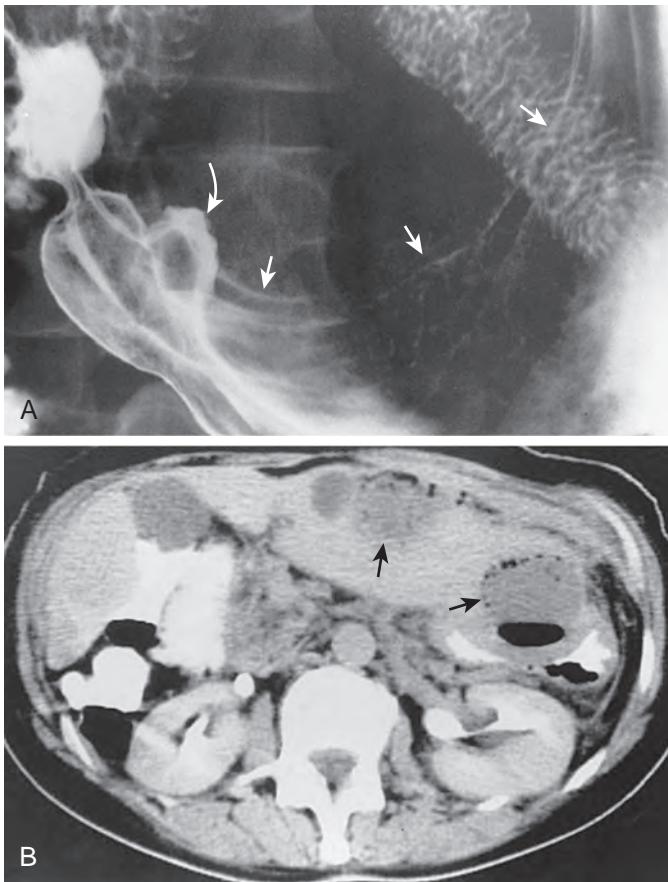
Penetrating lesser curvature ulcer with an associated hepatic abscess. A. Barium study shows a deep ulcer (curved arrow) on the lesser curvature of the distal antrum. Also note the large area of extrinsic mass effect (straight arrows) on the adjacent gastric wall. B. CT scan reveals several gas- and fluid-containing abscess cavities (arrows) in the left lobe of the liver. These abscesses were caused by penetration of the ulcer into the hepatic parenchyma.
